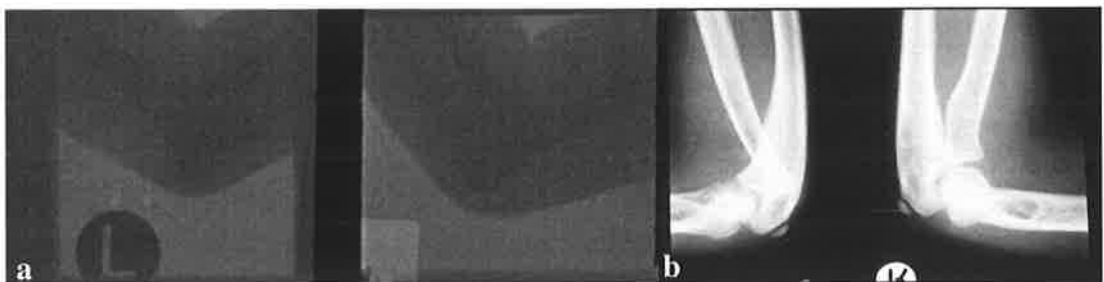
Elbow radiographs in two patients with Crouzon syndrome. (a) Complete humero-radio-ulnar synostosis. (b) Subluxation of the left radial head.
